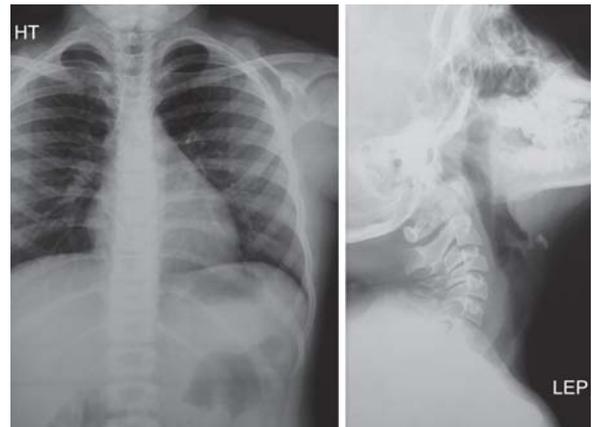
Normal chest and neck X-rays
